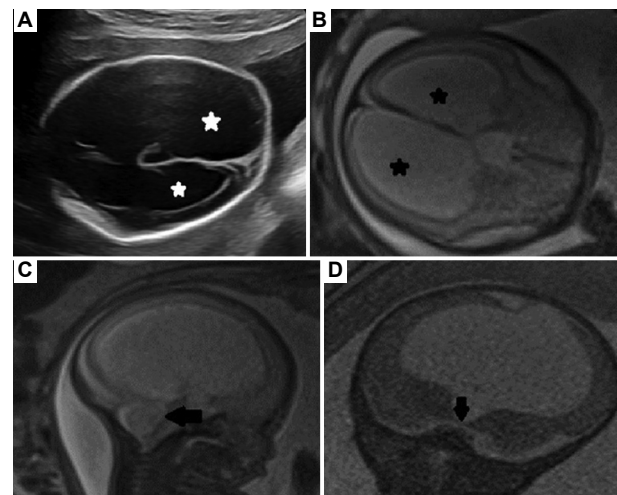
Imaging of congenital aqueductal stenosis. Severe ventriculomegaly is shown in (A) axial ultrasound and (B) axial HASTE image (white and black star). (C and D) The obstruction at the level of the cerebral aqueduct (black arrow) is visualized in sagittal HASTE and coronal TRUFI images. Abbreviations: TRUFI: True fast imaging with steady-state free precession; HASTE: Half-Fourier acquisition single-shot turbo spin-echo.
